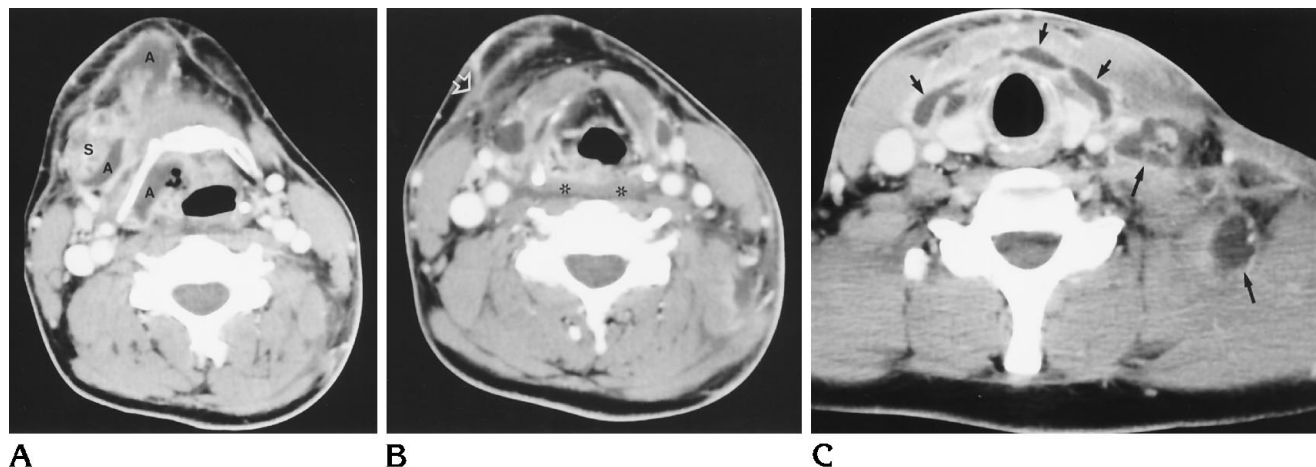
A, Axial contrast-enhanced CT scan at the level of the hyoid bone shows thickening of the epiglottis. Small abscesses (A) are seen medial to the right submandibular gland (S) and in the right anterior portion of the neck.
